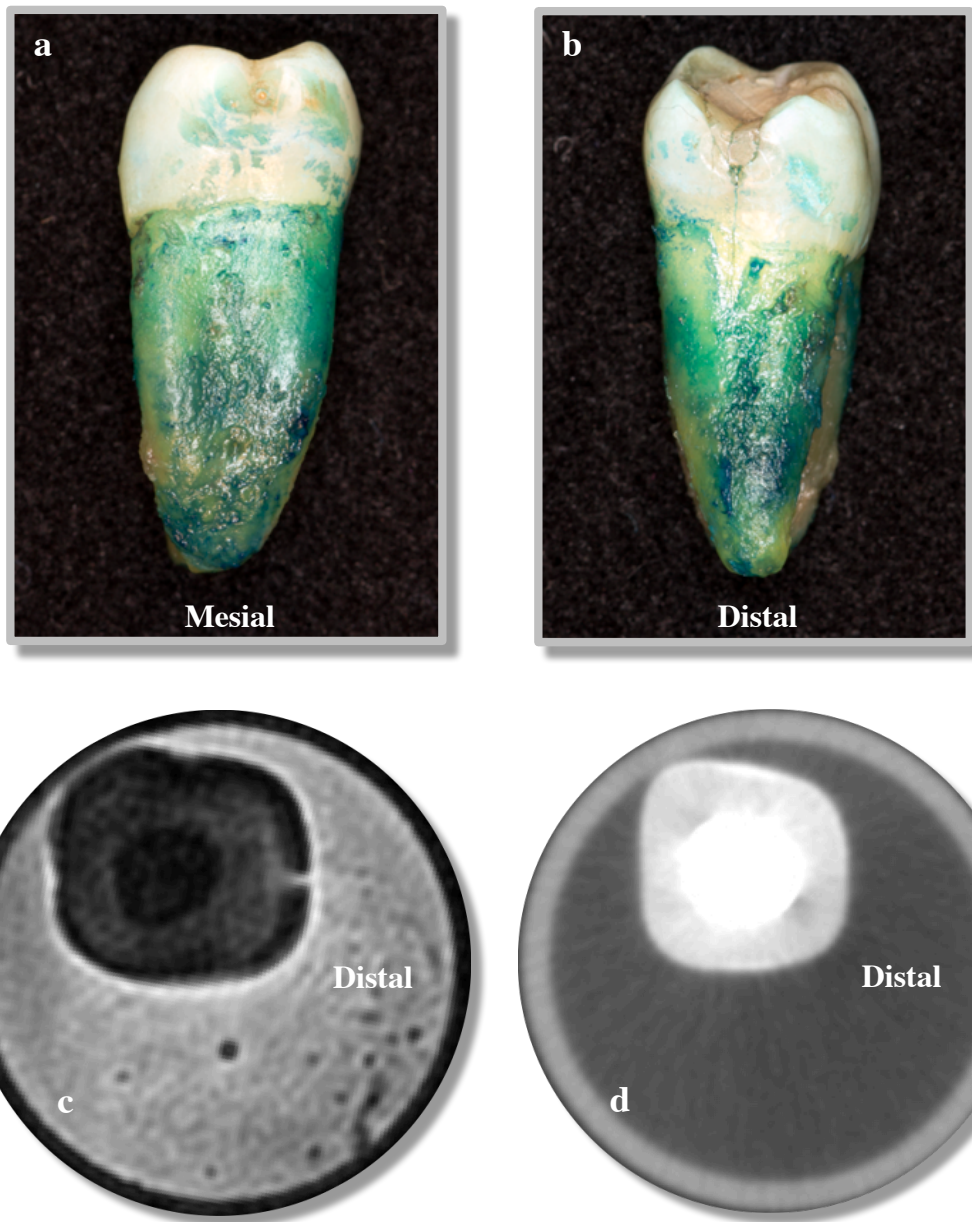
Mandibular 1st molar with a distal crack. Selected corresponding axial slices: SWIFT MRI (c) with notable absence of metal streak artifact from amalgam core, and limited FOV CBCT (d) with severe metal streak and beam-hardening artifacts.
